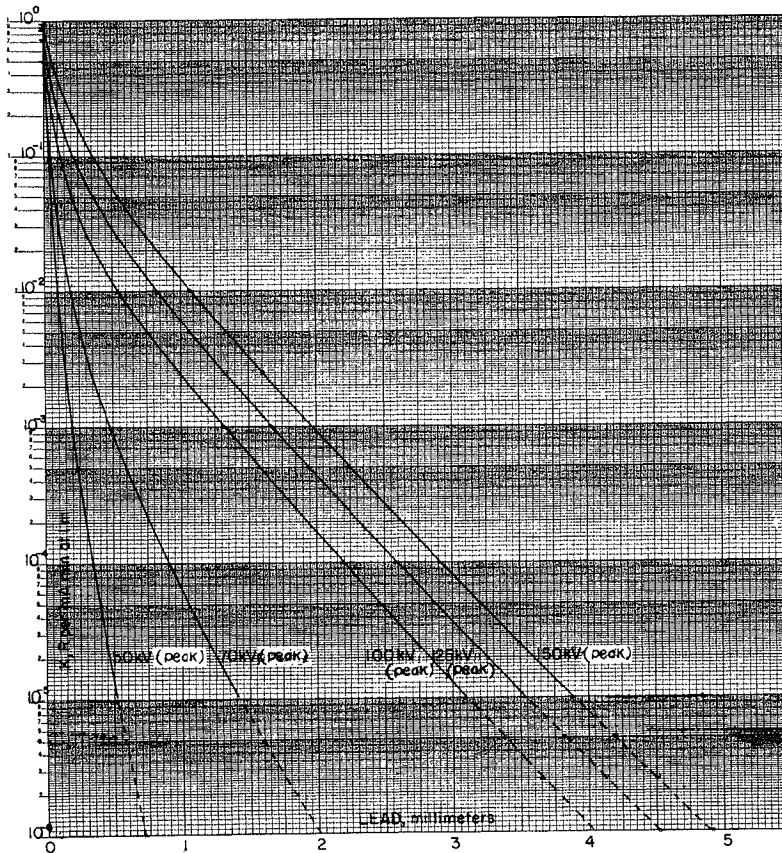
Attenuation in lead of x rays produced at potentials of 50 to 150 kV peak. The measurements were made with a 90° angle between the electron beam and the axis of the x-ray beam and with pulsed waveform. The filtrations were 0.5 mm of aluminum for 50 kV, 1.5 mm of aluminum for 70 kV, and 2.5 mm of aluminum for 100, 125 and 150 kV (Kelley and Trout [15]).
